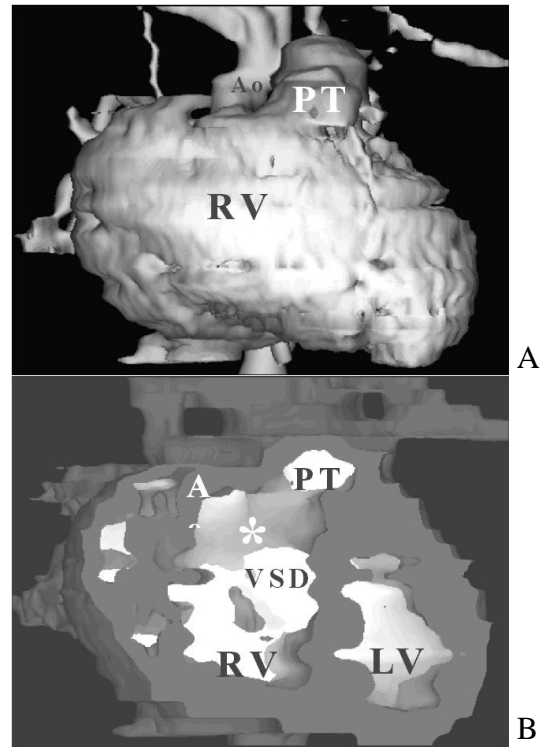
Doubly-committed VSD type of DORV. (A) 3D CTA revealed both PT & Ao arose from the RV with PT left anterior ( $31^{\circ}$ ) to Ao. (B) 3D inner cardiac view demonstrated the upper margins of the VSD just benign both great arteries. The conus septum (\*) formed an arch under both PT & Ao. Ao=aorta; LV=left ventricle; PT=pulmonary trunk; RV=right ventricle; VSD=ventricular septum.
